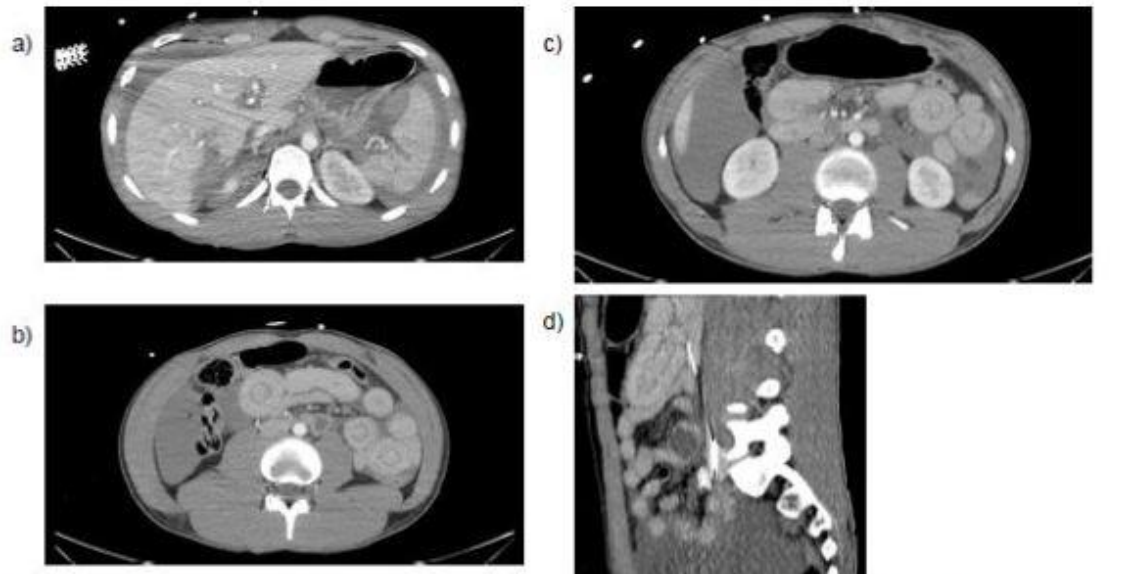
Axial (a-c) and sagittal (d) CT scan images of patient with high energy car accident. Image (a) displays splenic and hepatic lacerations, with hemoperitoneum. (b-d) shows many segmental yeyuno-yeyunal intussusceptions with clear "target sign" associated with thickening of the abdominal wall.
